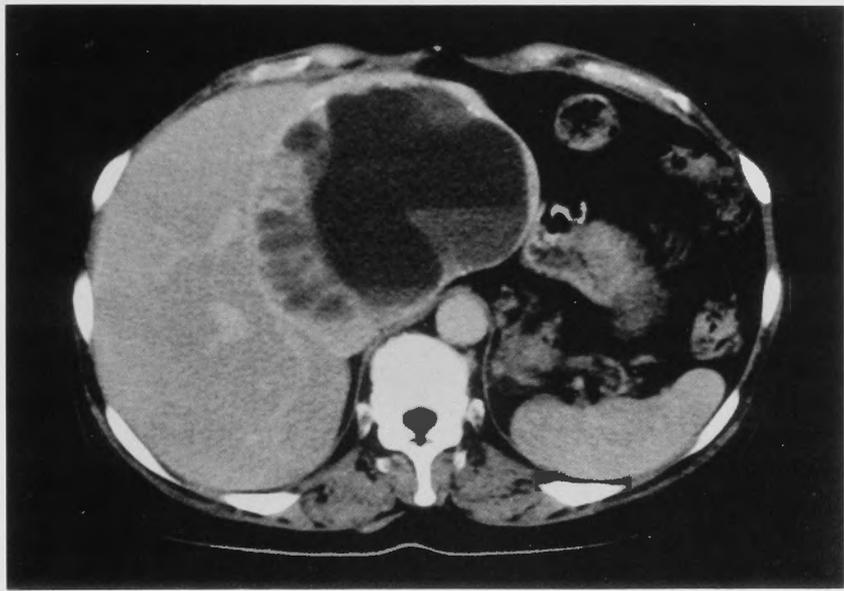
Computed tomography of the liver. Large cystic tumor is located in the left lobe of the liver.
